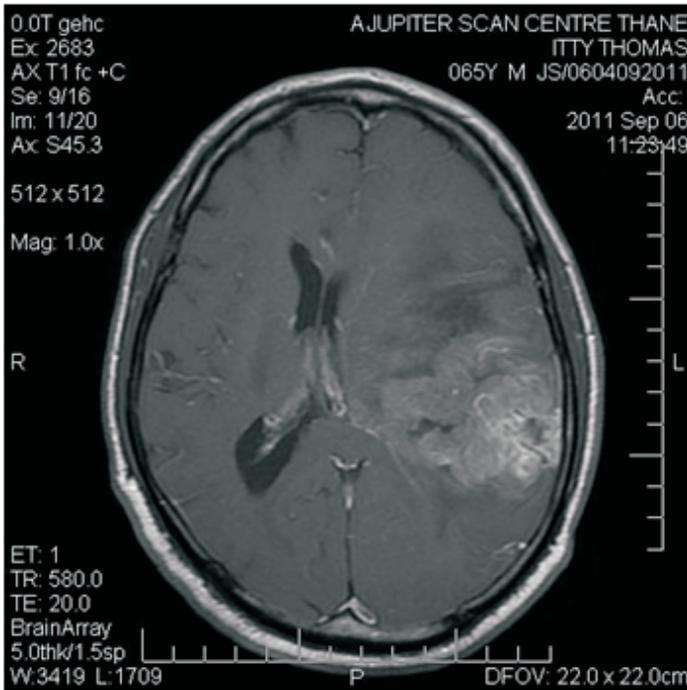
MRI Axial post-contrast T1 W images showing heterogeneous contrast enhancement by the mass lesion
